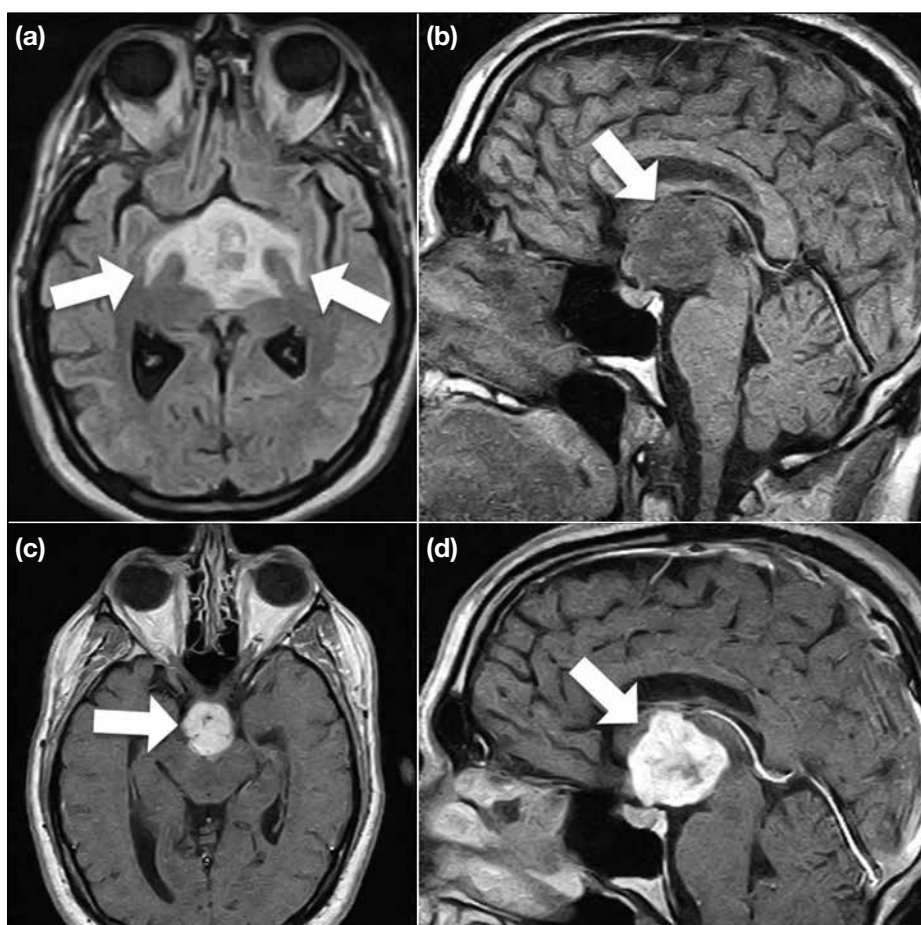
Glial cell tumour. The case displays suprasellar oedematous infiltration along both optic tracts (arrows) on nonenhanced axial T2-weighted fluid-attenuated inversion recovery image (a). The main tumour portion (arrows) is located in the suprasellar and retrochiasmatic region, with heterogeneous iso- to hypointensity on sagittal unenhanced T1-weighted image (b) and strong heterogeneous enhancement on the axial (c) and sagittal (d) T1-weighted enhanced images.
